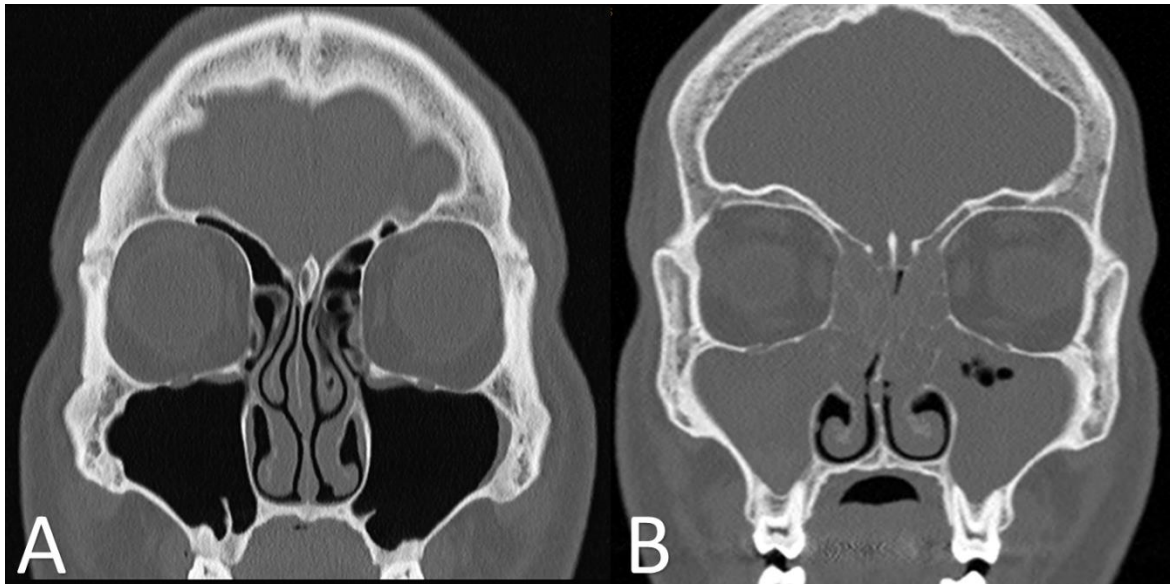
CT Sinuses (Coronal view).
